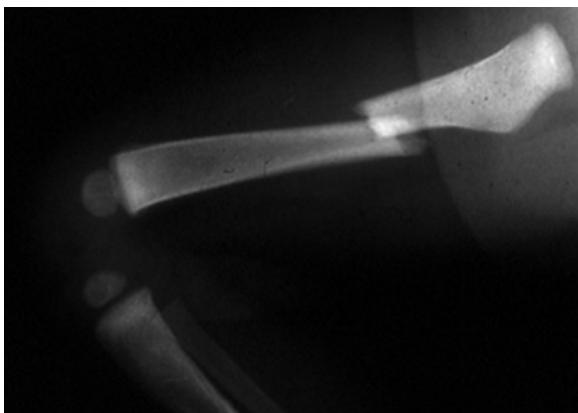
X-ray of right leg showing a displaced mid-shaft fracture of the femur.
